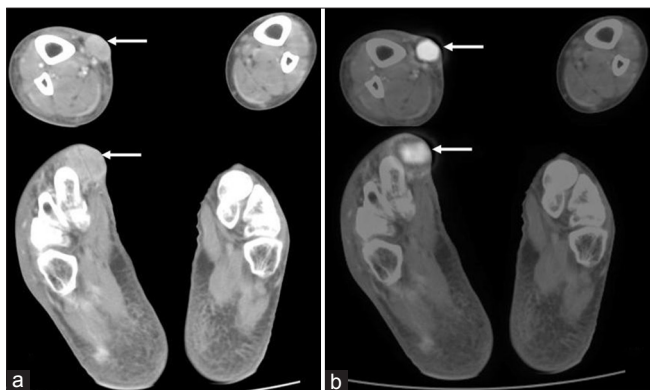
Axial contrast-enhanced computed tomography (a) and fused positron emission tomography/computed tomography (b) images of the leg (upper row) and foot (lower row) demonstrate multiple hypermetabolic mildly enhancing nodular lesions (arrows) involving the skin and subcutaneous tissue with no extension into the underlying muscles
